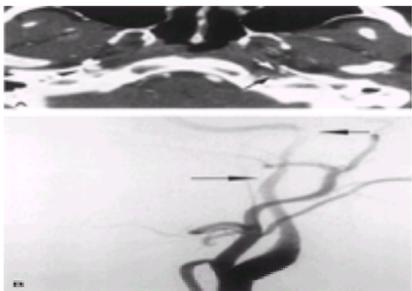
Internal carotid artery dissection in a 37-year-old man with headache and left pupillary constriction. A: Computed tomographic angiography at skull base shows decreased caliber of left internal carotid artery (*white arrow*) at the skull base. Intramural hematoma surrounds the narrowed lumen (*black arrow*). Normal right internal carotid artery (*arrowhead*). B: Left internal carotid arteriogram shows smooth narrowing of distal cervical internal carotid with near complete occlusion at the skull base (*arrows*).
